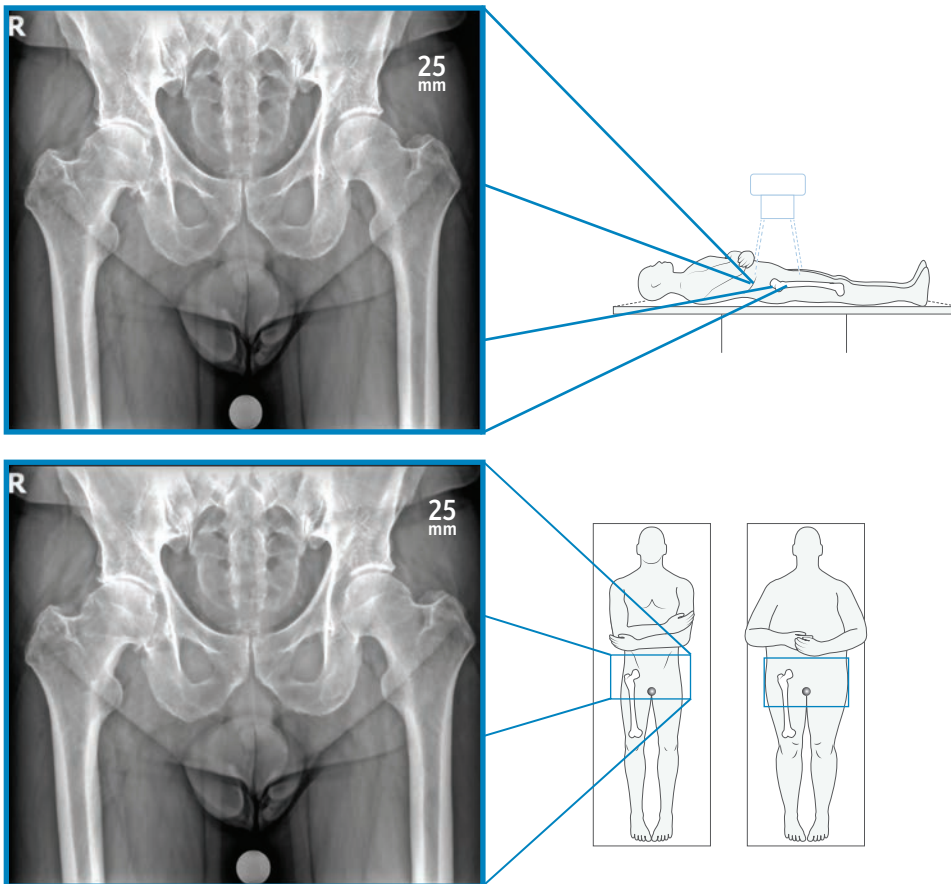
Preoperative Bilateral AP X-ray Side and Top View
